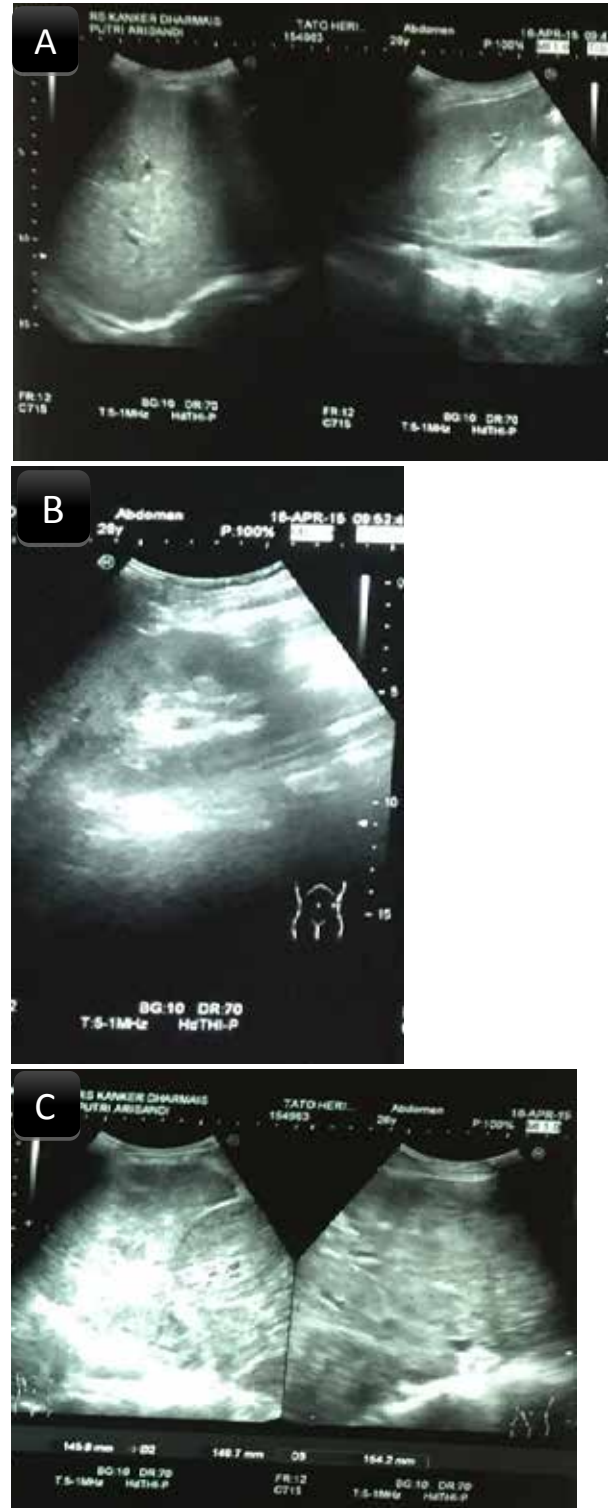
Follow-up abdominal ultrasound, (A) No metastasis on the liver, no mass on the right renal fossa; (B) Left kidney was normal; (C) Nodular mesenteric mass.
